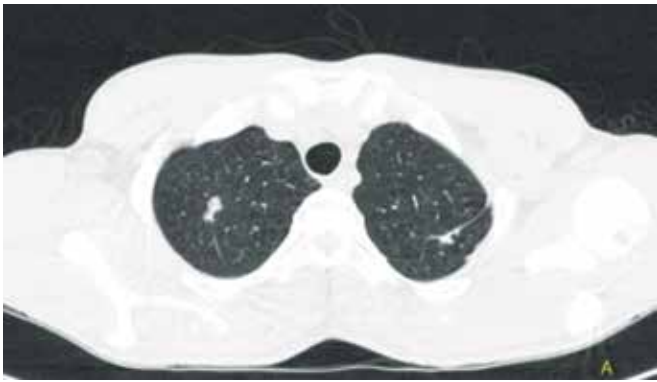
Computed tomography of chest showing bilateral reticulo-nodular opacities with burrow track in Case 2.
